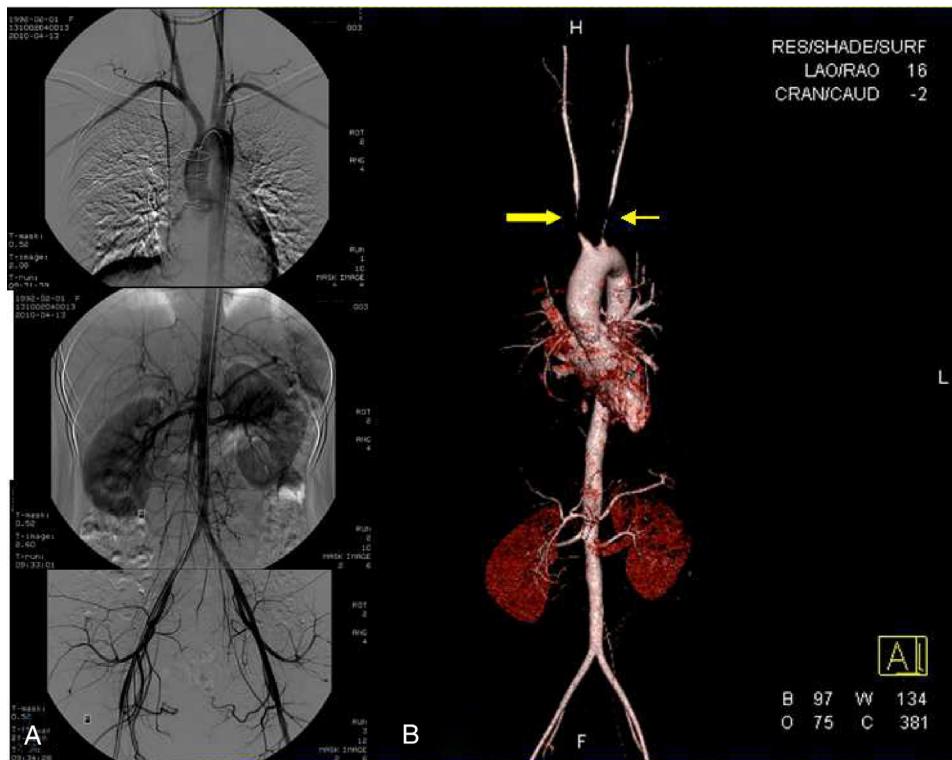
(A) Digital subtraction angiography of the aorta and branches after tricuspid valve annuloplasty. Images of thoracic aorta, abdominal aorta and iliac artery were integrated into one figure. It referred to no vascular lesions that involved the aorta and branches. (B) Computed tomography arteriograms of the aorta and branches 42 months after TA diagnosis. Considerably remarkable stenosis of the right brachiocephalic trunk (large arrow), left common carotid artery (small arrow) and subclavian artery was noted.
